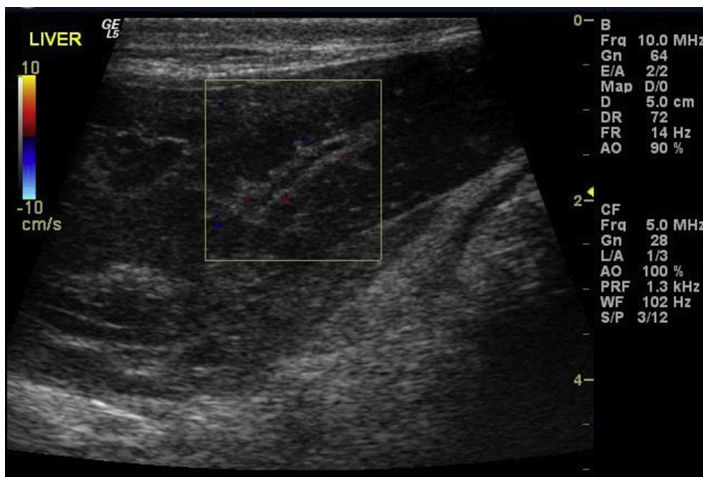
Sagittal sonographic image of a rabbit with a liver lobe torsion. The box over a portion of the torted lobe represents the region of sampling and demonstrates a lack of blood flow to the affected liver lobe. Note the decreased echogenicity of the lobe and the surrounding hyperechoic fat, common findings seen on ultrasound of liver lobe torsions in rabbits.
